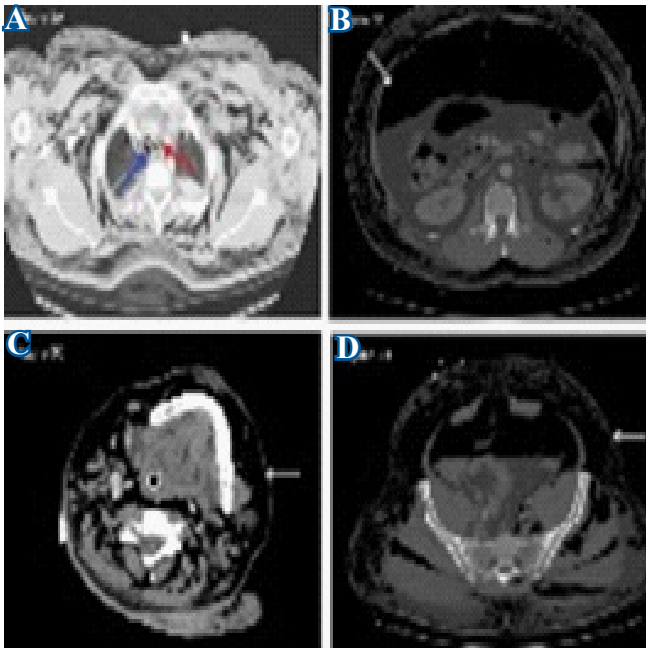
Contrast-enhanced CT scan of the chest showing suspected loss of integrity in the posterior trachea near the endotracheal tube with surrounding air densities (blue arrow), widespread air densities in the mediastinum (pneumomediastinum) (red arrow), widespread air densities in the subcutaneous tissue (subcutaneous emphysema), and fluid densities in both pleural spaces (pleural effusions).
